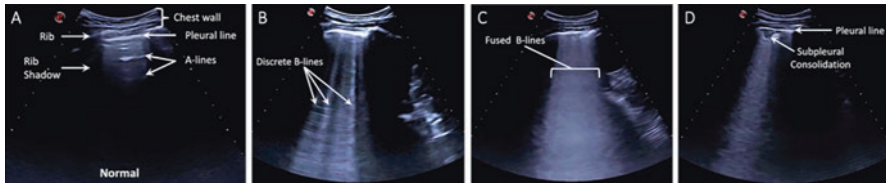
Lung ultrasound patterns of coronavirus disease-2019 (COVID-19). *Notes:* (a) Normal lung with pleural sliding and A-lines; (b) discrete hyperechoic individual B-lines which are usually the first signs of COVID-19 and are due to increased interstitial fluid in the acute disease stage; (c) confluent B-lines are formed by coalescence of many individual B-lines as the disease progress and more interstitial fluid is accumulated; (d) subpleural consolidations (usually are small and <3 cm). (Source: Mateos González et al. (2021))
